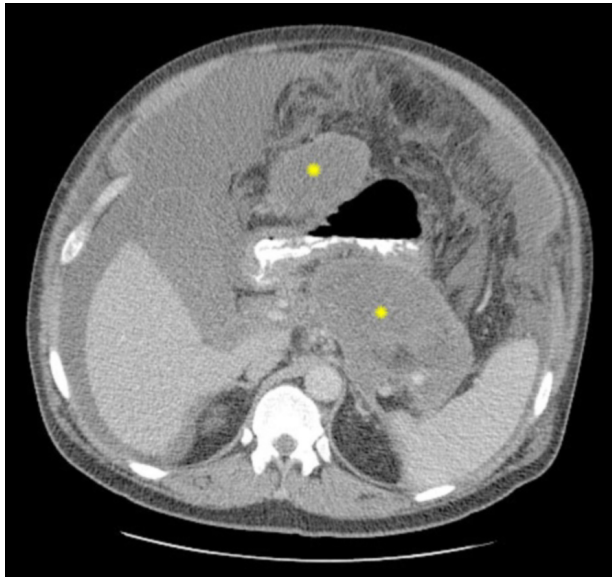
CT at the level of gastric emptying into the duodenum, with the pseudocyst (\*) visibly compressing the stomach anteriorly and posteriorly.
